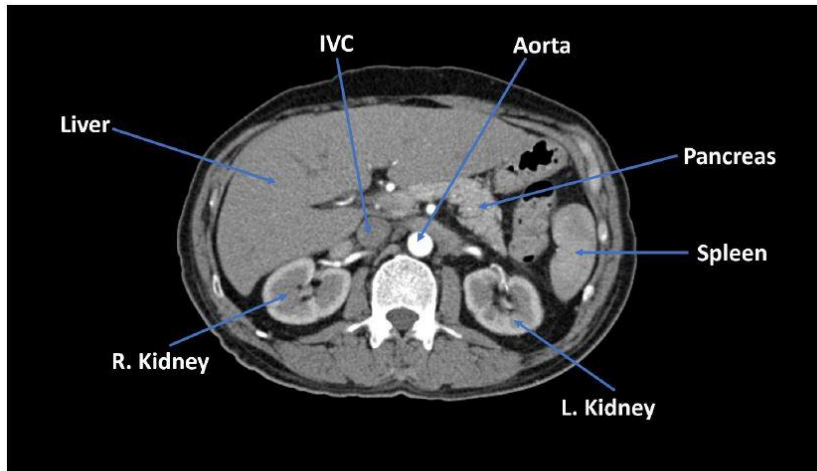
Normal liver CT
